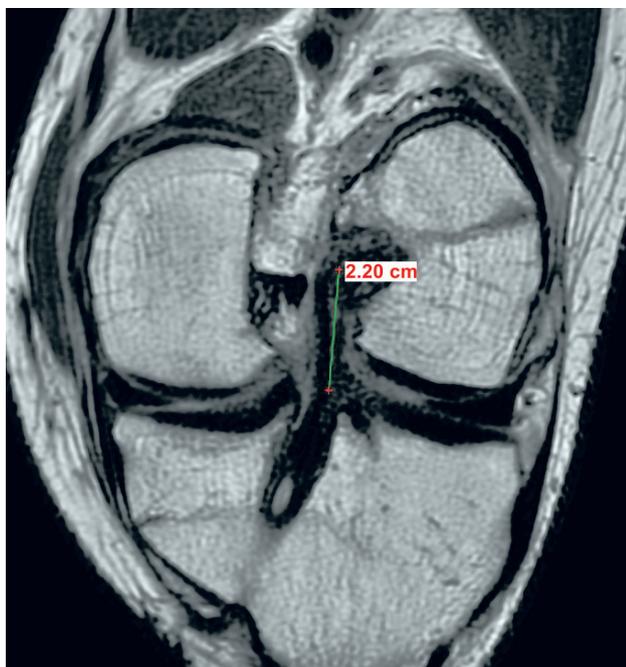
Measurement of reconstructed ACL length performed on axial ACL scans in MRI
